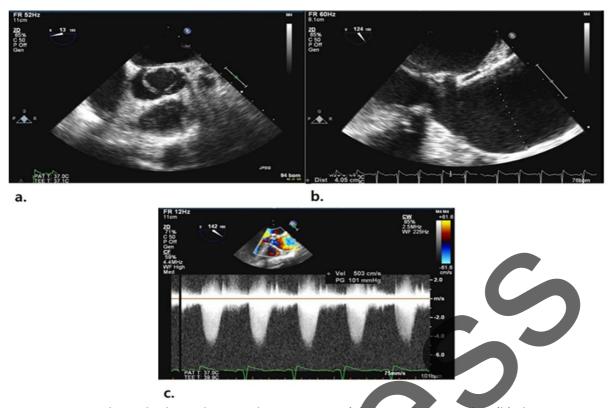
Transesophageal echocardiogram demonstrating. (a) Bicuspid portic valve. (b) The aortic root. (c) Color
